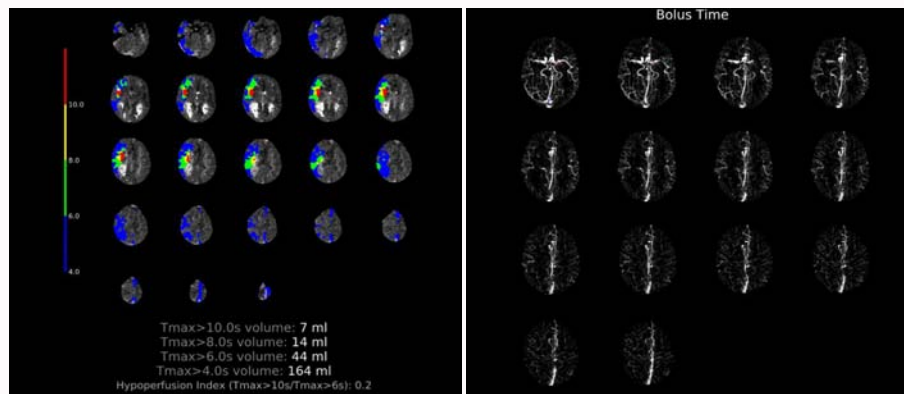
CT Perfusion also showed good collaterals as evidenced by a Hyperperfusion Index (HIR) of 0.2. Low HIR (< 0.5) indicates good collaterals = slow infarct core growth.
